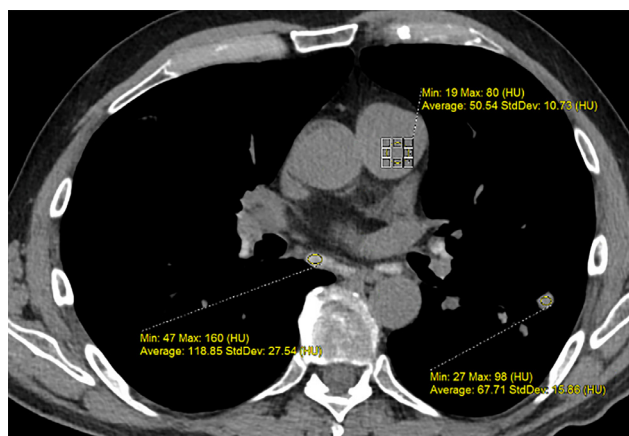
Chest CT with contrast, soft tissue window showing Hounsfield units of a blood-filled vessel, a nodule in the left lower lobe, and a lymph node. The nodule is shown to have an average reading of 67.71 Hounsfield units (HU) and the lymph node 118.85 HU, making them both hyperdense in comparison to the 50.54 HU measured in the blood.
